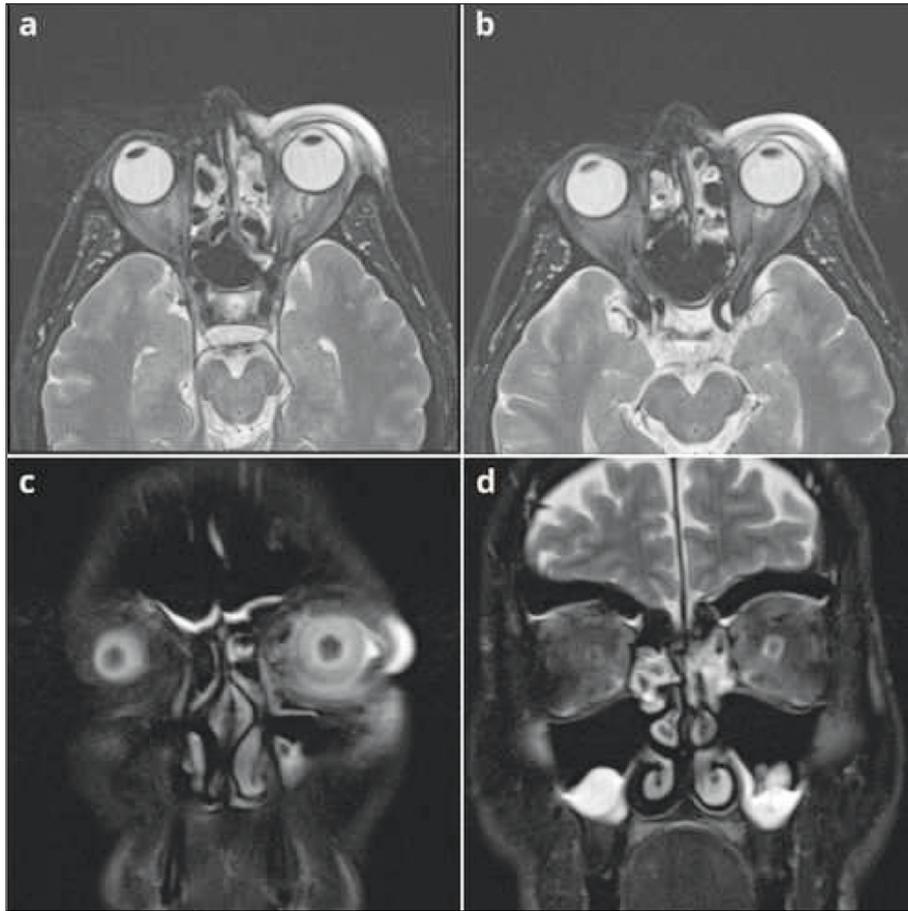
Magnetic resonance imaging of the patient with different angles and sequences, there was an increase in the skin and subcutaneous distance in the soft tissues around the left eye orbit and an increase in the cerebrospinal fluid distance around the optic nerve, orbital cellulitis.
